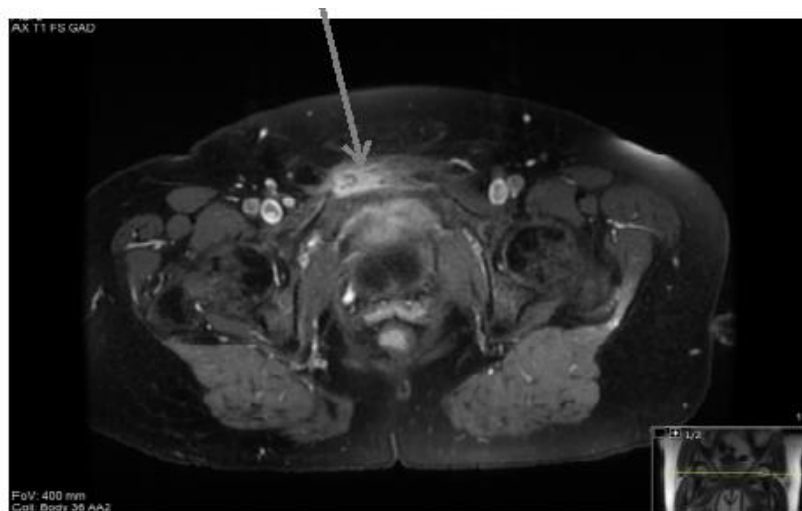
Area showing enhancement of osteomyelitis and associated reactive changes seen on the right pubic symphysis (on MRI Gadolinium sequence).
